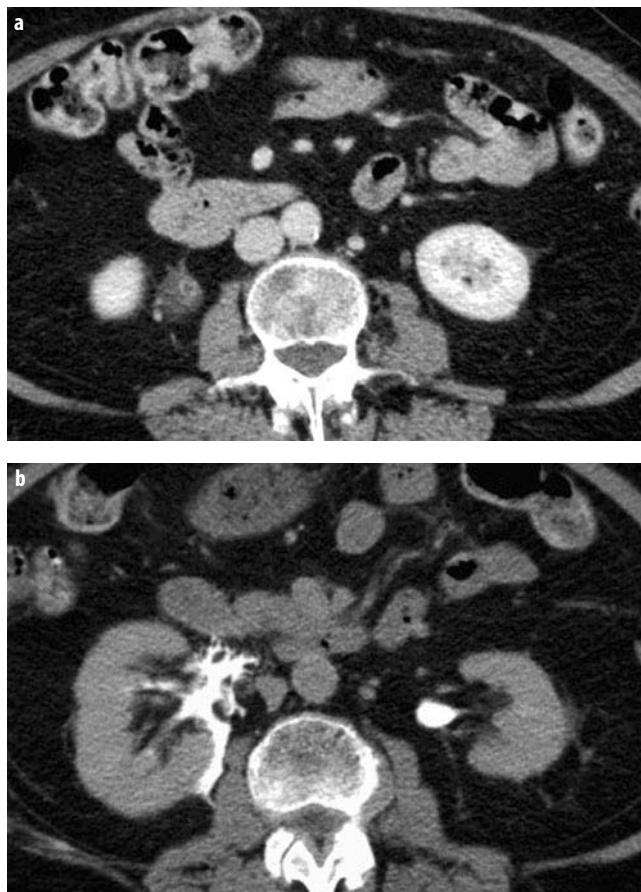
a, b. Routine trauma CT image shows fluid and stranding about the right ureter. a Note that contrast filling of the ureter has not yet occurred. Delay image shows extravasation medial to the kidney typical, of UPJ avulsion. b Note the intact parenchyma
